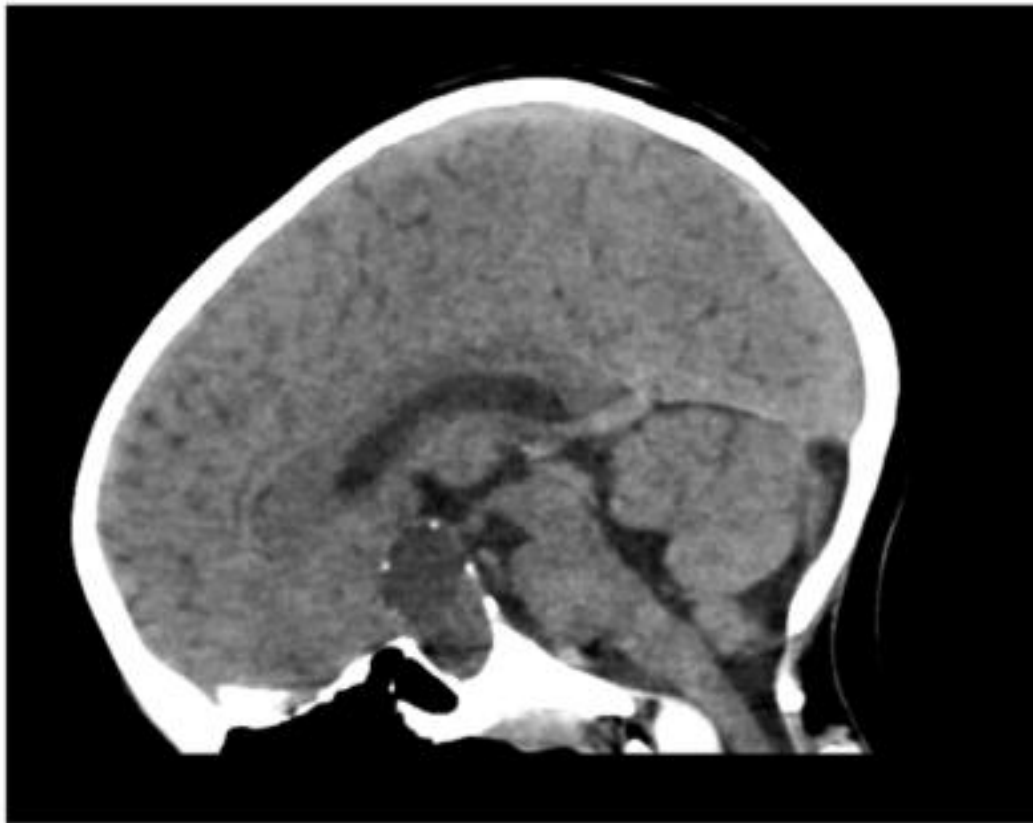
CT scan of adamantinomatous craniopharyngioma (ACP) showing large cyst with flecks of calcification around the cysts.
